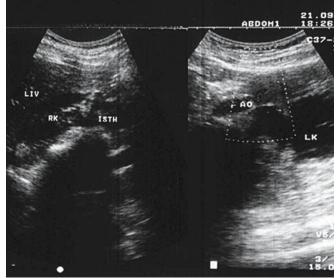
Ultrasound scan shows a horseshoe kidney with very thick isthmus and left moiety UPJ obstruction
